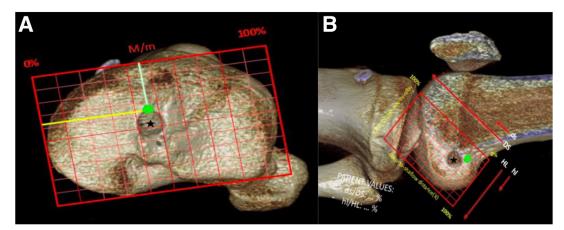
Three-dimensional computed tomography scan of the right knee showing the previously constructed anterior cruciate ligament tibial tunnel (black star) is posterior in relation to the anatomical tibial footprint (green dot) according to the Bernard-Hertel grid (A). (B) The femoral tunnel (black star); in this case it seems anterior in relation to the ideal femoral tunnel (green dot).
